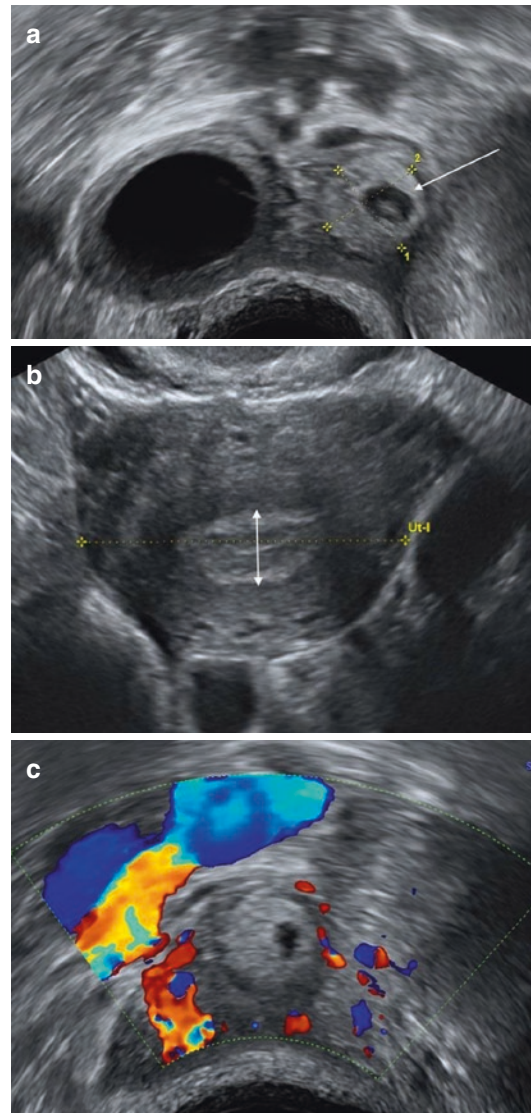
Ectopic pregnancy in a 15 year-old girl. Endocavitary US. (a) US Axial view: Complex adnexal mass (arrow) separate from the ovary that contains a corpus luteum. Hyperechoic crown around the gestational sac. (b) US Axial view: Vacuity of uterine cavity which contrasts with an endometrial thickening. (c) Energy Doppler US: Reactional hypervascularization around the mass
